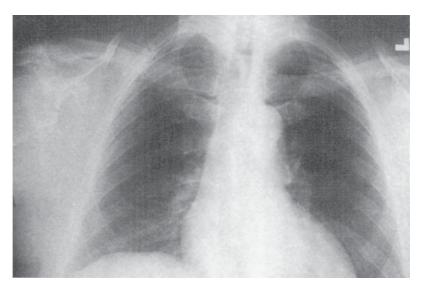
PA chest radiograph. Note the clarity of the clavicles and the anterior ribs.
